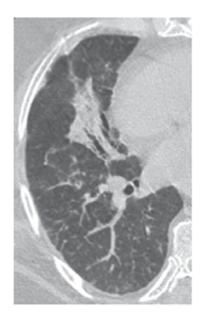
A 54-year-old female with sarcoidosis. CT of the chest shows a large alveolar density in the right middle lobe
